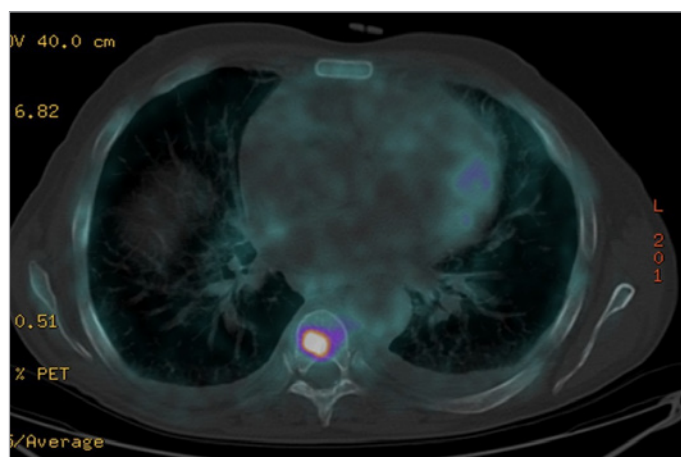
Bone involvement by PET-CT in Erdheim-Chester disease (II).
